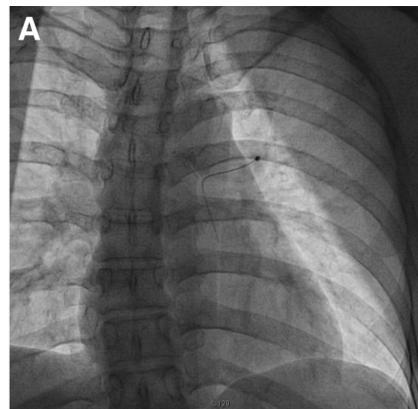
A, Chest x-ray with foreign body. B, Computed tomography scan of chest with embolized catheter segment between the pulmonary artery trunk and the left pulmonary artery. The distal end of the catheter is surrounded by a 3.7-mm-diameter calcified tissue mass.
